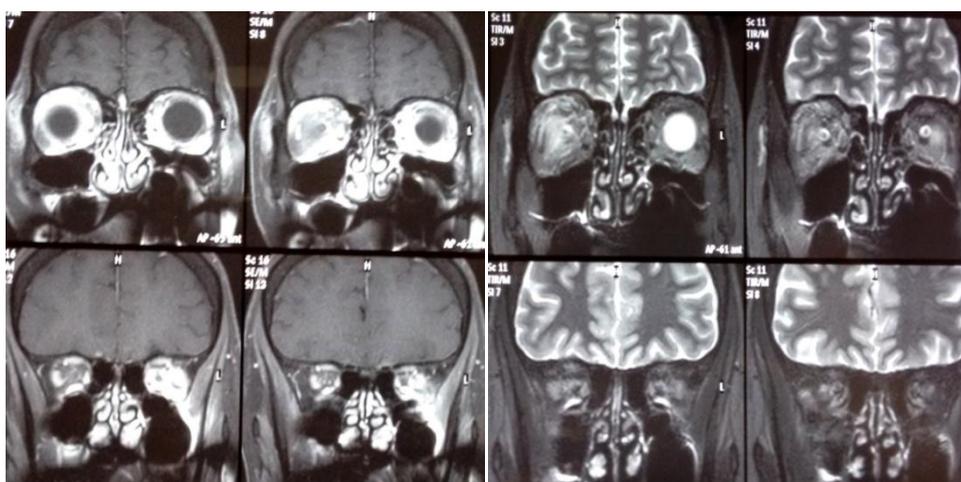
MRI; coronal plane- reveals diffuse ill defined heterogeneous soft tissue enhancement & fat stranding of right orbit.
